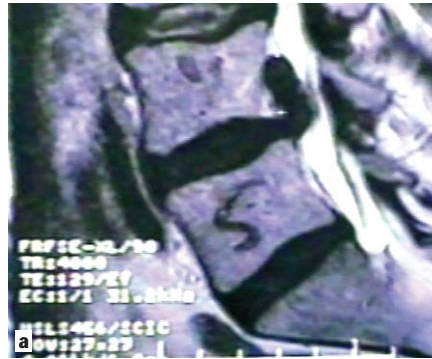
Lateral and axial MRI of an extruded, sequestered HNP L4-5 left.
